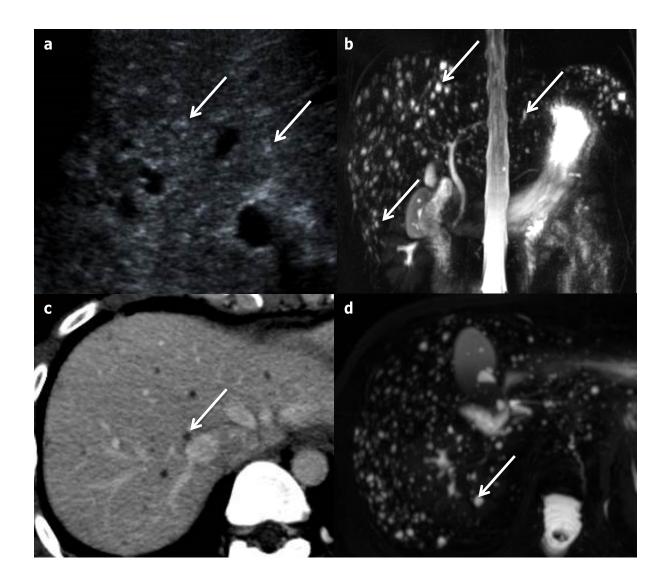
Bile duct hamartomas in a 52-year-old female patient. (a) Multiple hyperechoic round nodules (arrows) at ultrasonography, seen as "snowstorm". (b) Coronal magnetic resonance cholangiopancreatography shows several small hyperintense nodules not communicating with the biliary tract (arrows). (c) Axial computed tomography at portal-venous phase shows bilobar, small hypoattenuating round nodules, better detected on an axial magnetic resonance cholangiopancreatography sequence (d).
